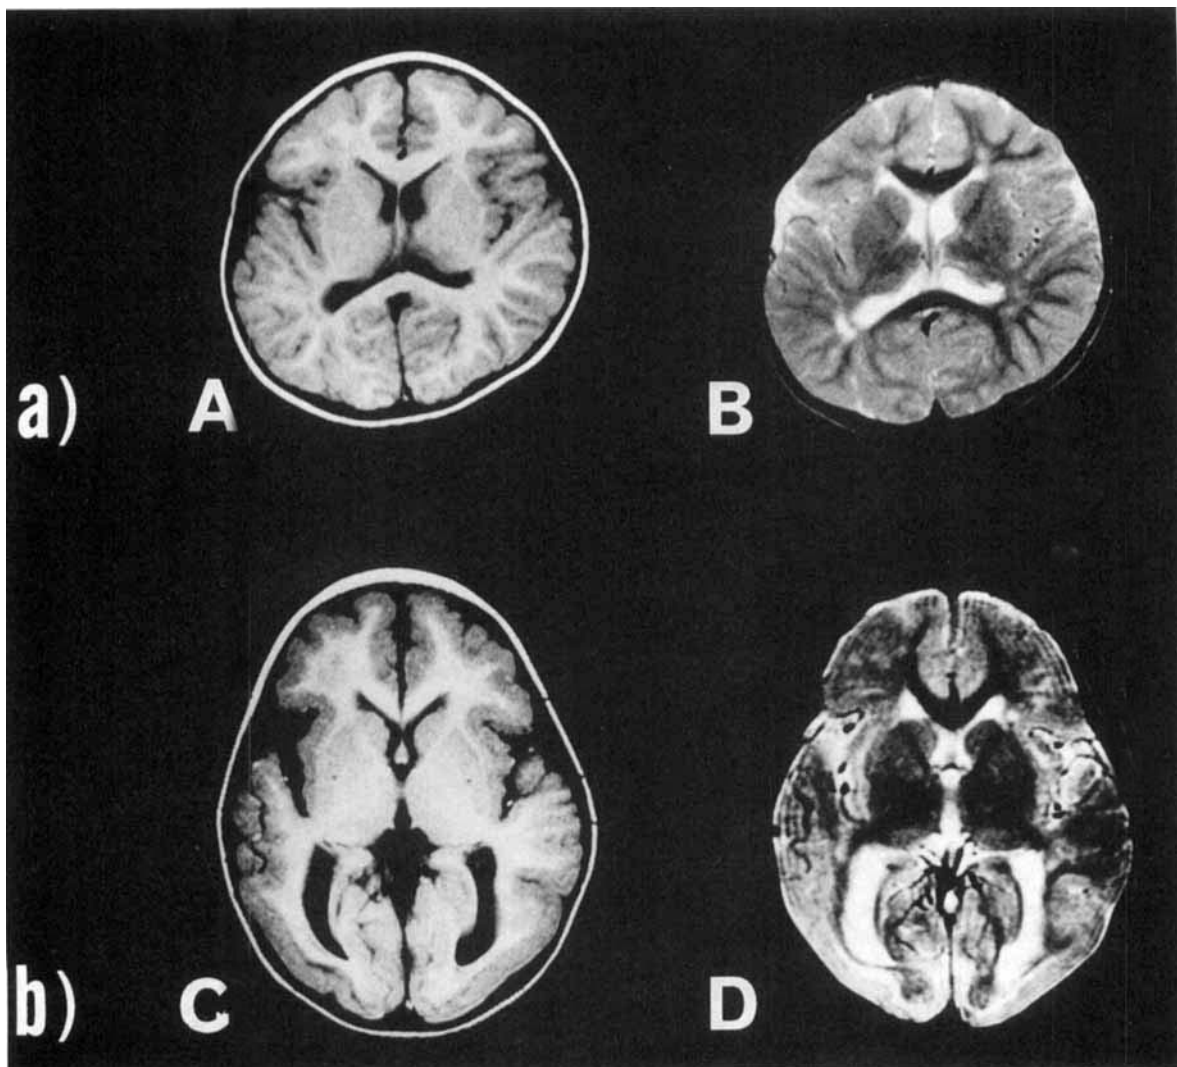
Brain MRI of the probands of family 1 (a) and of family 2 (b). A and C are T1-weighted inversion-recovery images, and B and D T2-weighted spin-echo images. Delayed myelination, mild ventricular enlargement, dilated Sylvian fissures (operculum dysgenesis) and pachygyria are evident.
